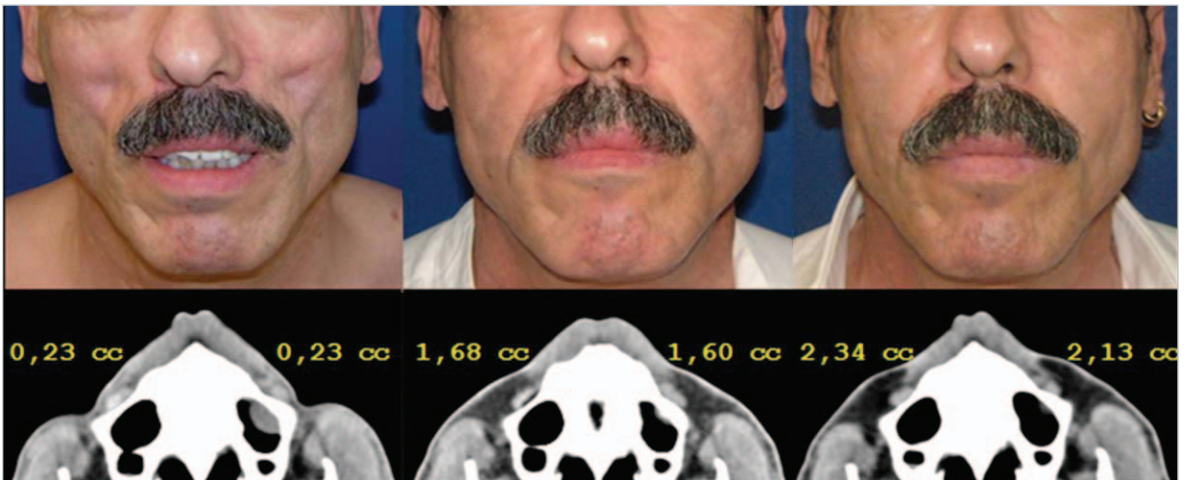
This 41-year-old woman demonstrates grade 2 facial lipoatrophy. In each side of her face, 9.6 cc of fatty tissue was injected. The numbers indicate the volume of fat detected by CT scan in a fixed cheek area before treatment and 2 and 12 months postinjection.
